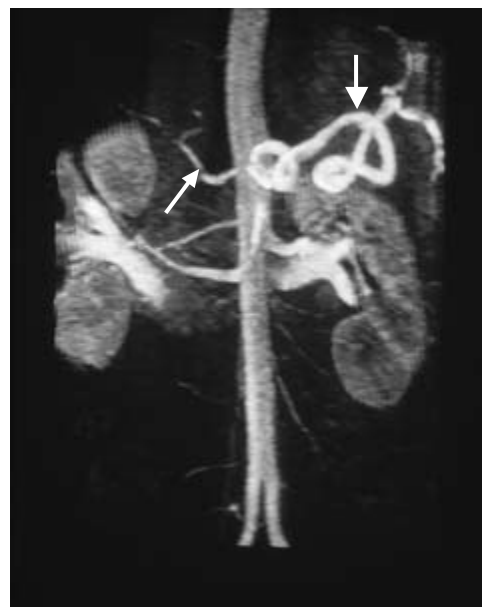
MRI (T_2 -weighted) angiogram showing the hepatic artery (small arrow) and tortuous splenic artery (large arrow) as well as the renal vessels below.
